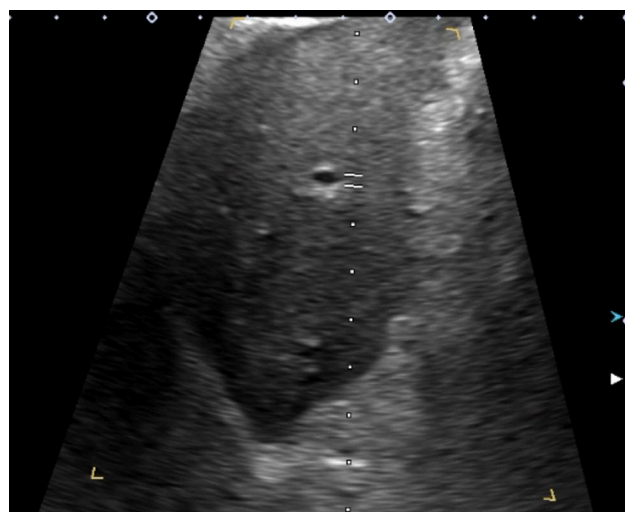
Gray scale ultrasound liver with coarsened echotexture and nodular surface.
